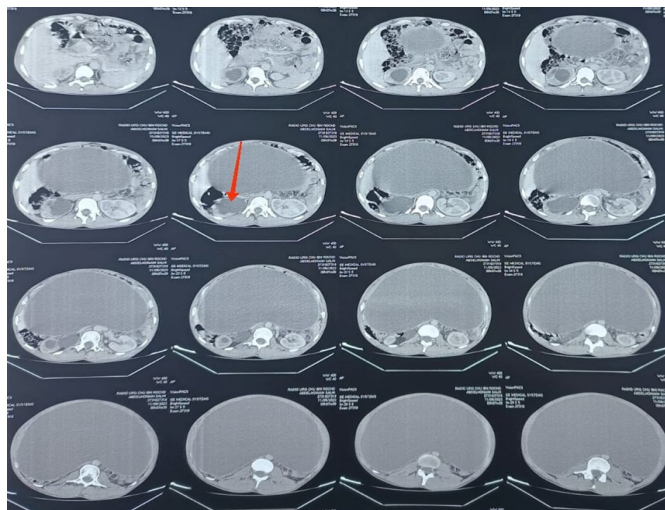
CT scan showing the abdomino-pelvic cystic mass and the right uretero-hydronephrosis (red arrow)
